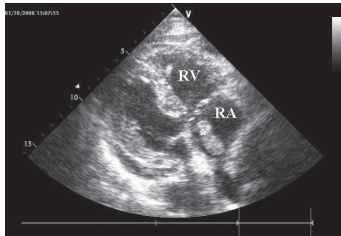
Transthoracic echocardiographic view showing right atrial thrombus by asterisk (RV=right ventricle, RA=right atrium).
